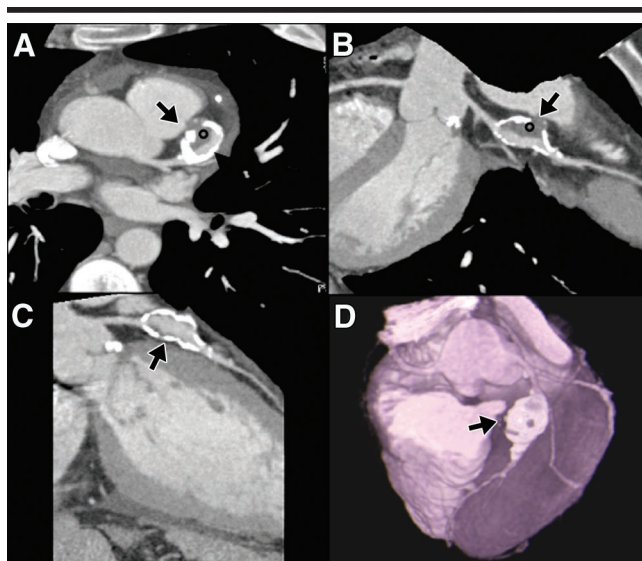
Coronary artery aneurysm (Kawasaki disease) at four-detector row CT. *A*, Oblique transverse thin maximum intensity projection, *B*, *C*, craniocaudal curved multiplanar reconstructions, and *D*, left anterior oblique volume-rendered surface reconstruction demonstrate calcified fusiform aneurysm (arrows) of the proximal middle LAD coronary artery containing thrombus (circles).
